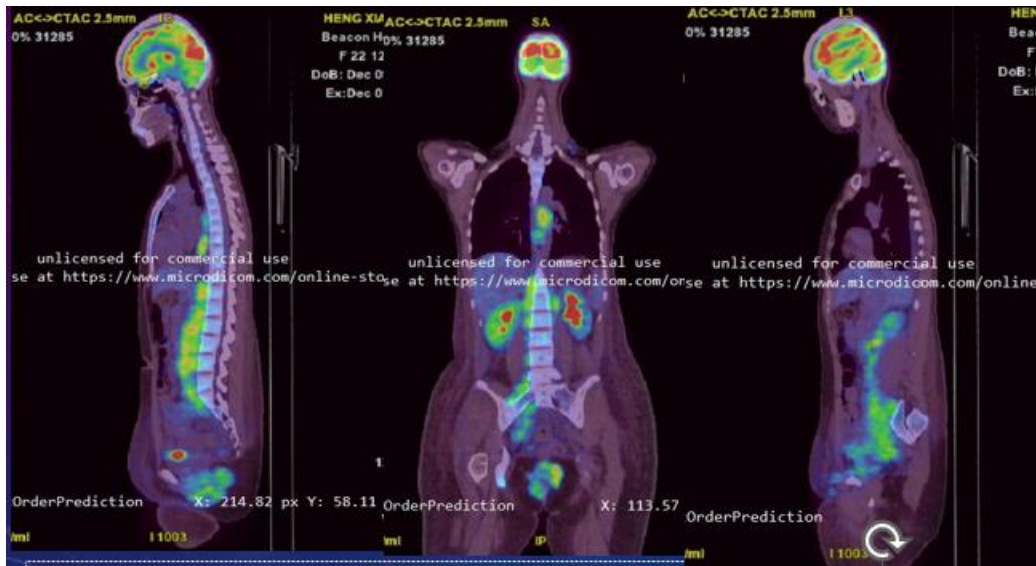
PET-CT scan showed increased FDG uptake mass at the perineum extending to the gluteal cleft measuring 6.9x5.6x6.2cm with multiple matted intra-abdominal LN
